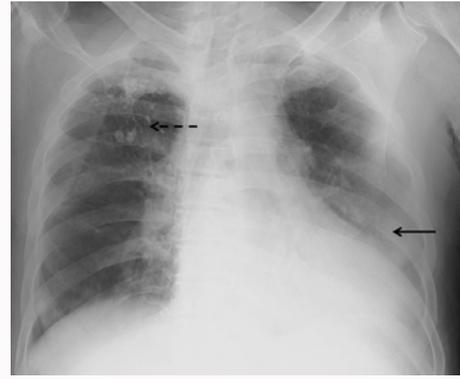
AP chest radiograph of 72-year-old male, known case of pulmonary tuberculosis with air space opacification involving left mid and lower zone (black arrows). Note the presence of fibro-infiltrative lesion with calcification in right upper zone (dashed arrow).
